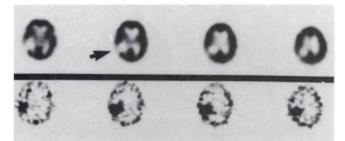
Axial SPECT images of a patient with SCLC brain metastasis. The HMPAO study (top row) shows decreased perfusion at the tumor site (arrow) with increased IAZA uptake (bottom row).
